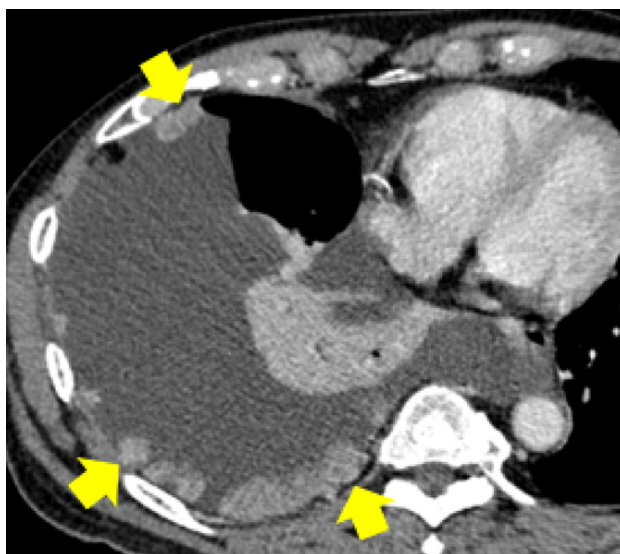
A 66-year old man with lung cancer and right pleural metastasis-standard reconstruction chest CT images show multiple various size enhanced pleural nodules along the right hemithorax (arrows). Also noted large amount of right pleural effusion with adjacent compressive atelectasis of the right lower lobe. atelectasis of the right lower lobe.
